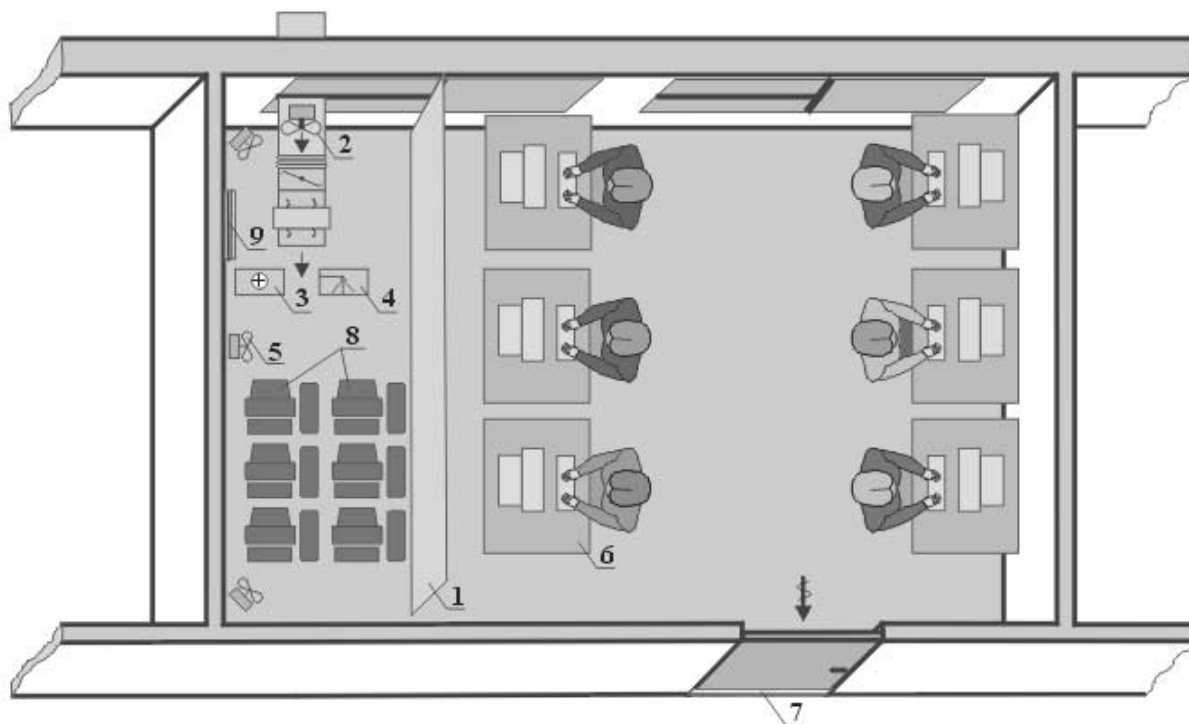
Experimental set-up in the office where the investigation was carried out: 1, partition; 2, axial fan with damper and silencer; 3, electric heater; 4, ultrasonic humidifier; 5, mixing fan; 6, workstation consisting of a table, a desk lamp and a PC monitor with keyboard; 7, exhaust aperture (a slot under the door); 8, six 3-month-old PCs running in screen saver mode; 9, SPLIT-type air conditioner. In the figure, the subjects are sitting at the workstations and the pollution source is present in the office (six PCs placed behind the partition)
